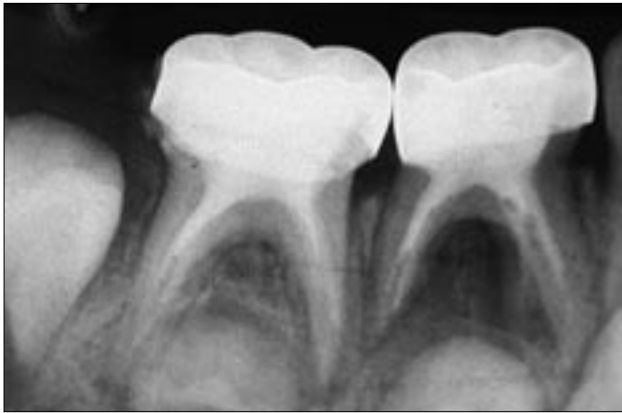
Immediate postoperative radiograph. Note underfilling of both teeth.
